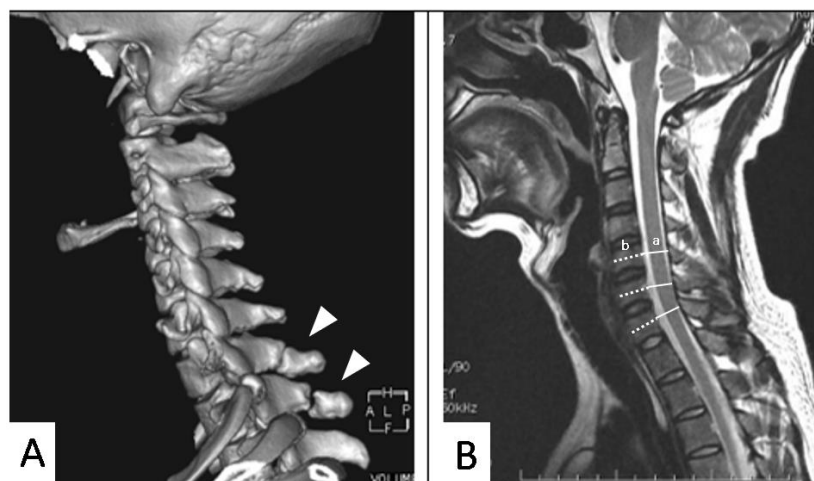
(A) Cervical CT scan revealed fracture on processus spinosus C7 and T1 (arrow head) and (B) Cervical MRI showed Torq-Pavlov ratio 0.93 on subaxial level (a/b)
